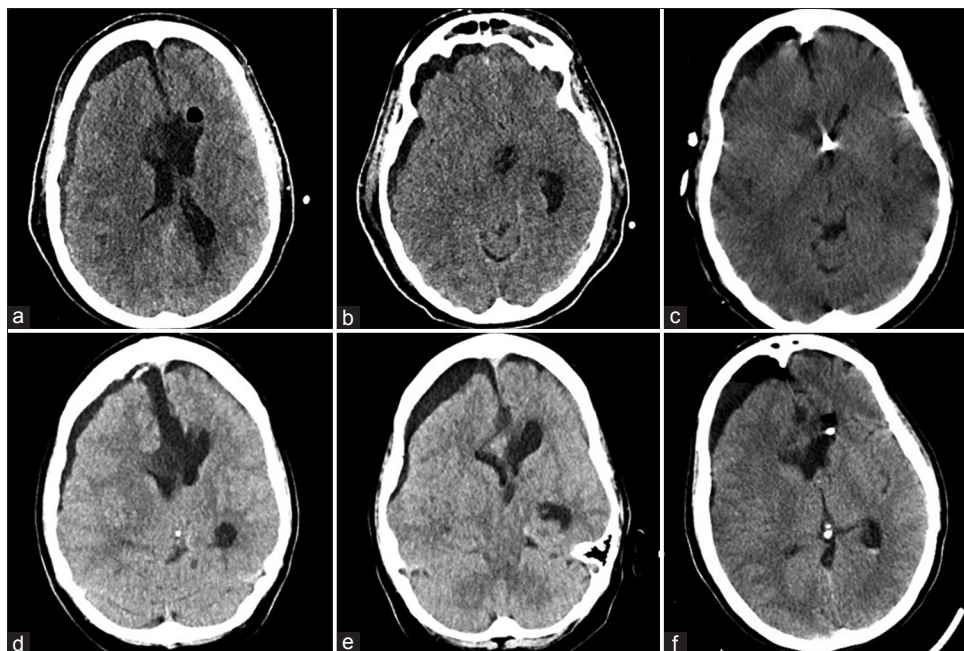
(a and b) Noncontrast head CT following postoperative neurological worsening shows a right hemispheric subdural fluid collection with mass effect and midline shift. (c) Noncontrast head CT after evacuation of the subdural collection and right frontal EVD placement shows improvement in mass effect and midline shift. (d and e) Non-contrast head CT, 3 weeks later, shows recurrence of the right subdural hygroma with concomitant ventriculomegaly, consistent with external hydrocephalus. (f) Non-contrast head CT after permanent CSF diversion shows reduction in subdural collection size and mass effect
